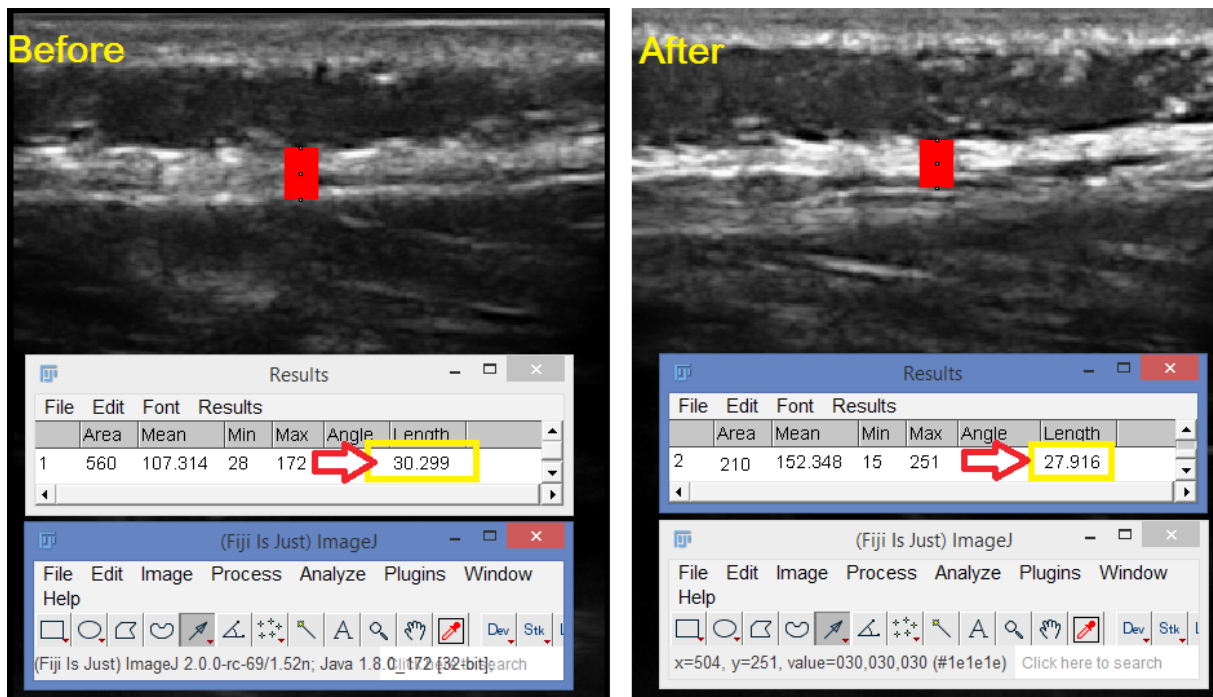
Ultrasound imaging of the thoracolumbar fascia
